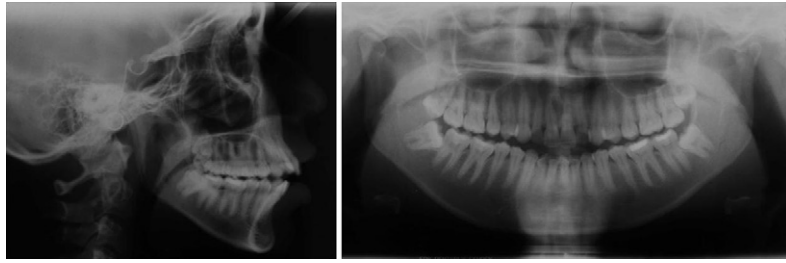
Initial cephalometric and panoramic radiographs of case 3.
